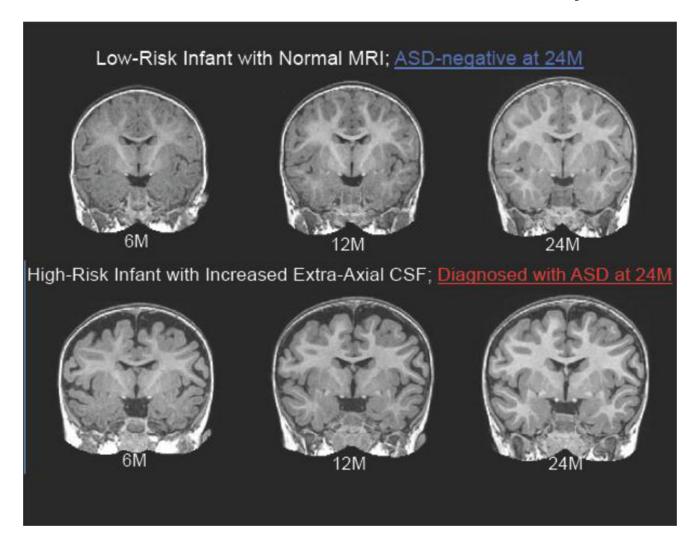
Example brain images indicating the presence of increased extra-axial CSF (A) T1-weighted coronal images of a low-risk infant with normal MRI at 6, 12, and 24 months. (B) T1-weighted coronal images of a high-risk infant with increased extra-axial CSF at 6, 12, and 24 months. This child was diagnosed with ASD at 24 months.
